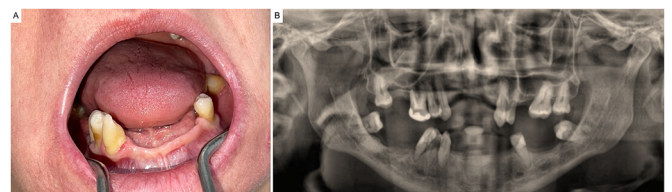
(A) Intraoral clinical image emphasizing the lower jaw. It shows a partially edentulous patient with a thin and atrophic alveolar ridge. (B) Panoramic X-ray image showing missing teeth.
